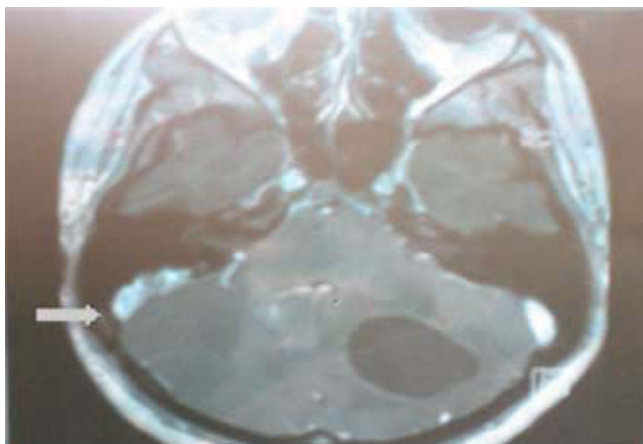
Cranial MRI: right endolymphatic sac tumour (arrow).
